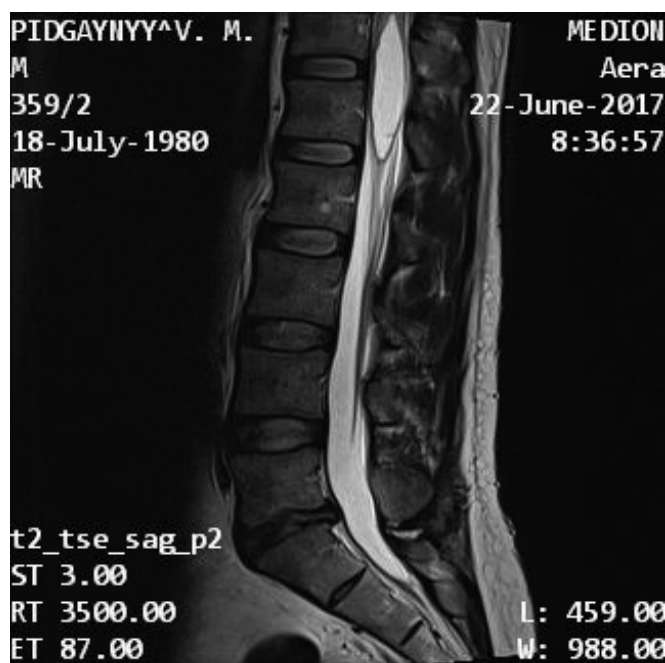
MRI with contrast enhancement of the lumbar spinal cord.
